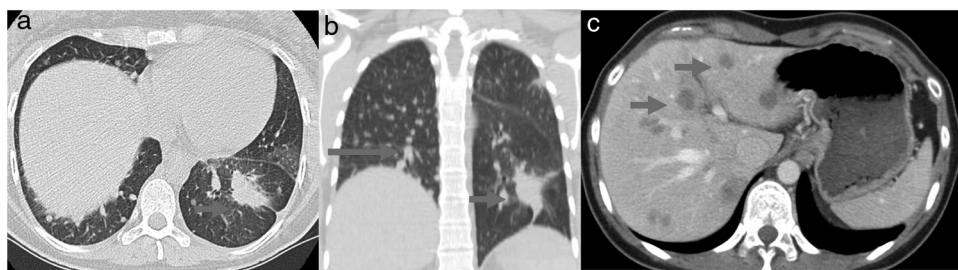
(a) Chest axial CT; (b) non-contrasting coronal CT shows left lower lung mass (arrow) and multiple small diffuse round nodules (long arrow) at diagnosis; (c) contrast axial abdominal CT shows multiple hypo-enhanced solid liver nodules according to diffuse liver metastases (arrows) following hepatic progression.
